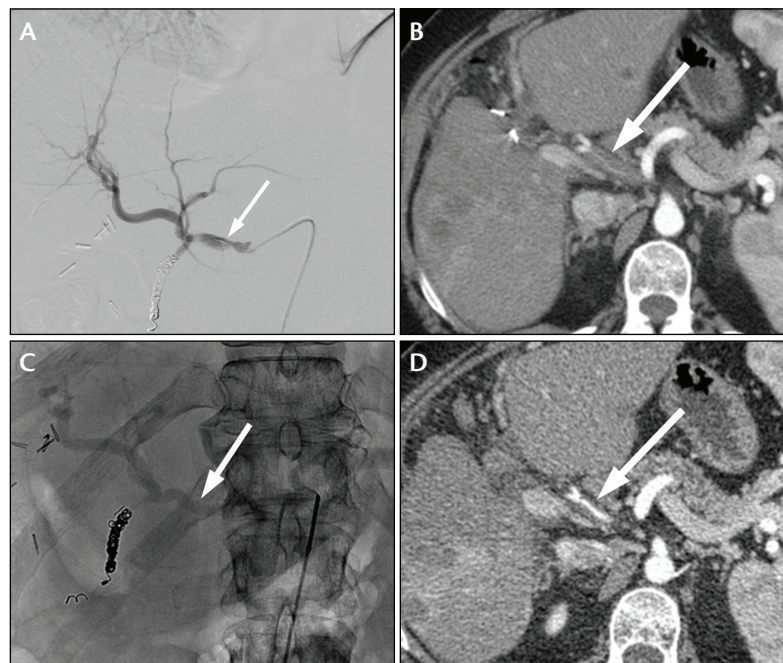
Common hepatic arteriography showed a flow-limiting dissection flap in the common hepatic artery. The GDA had been coiled in preparation for yttrium-90 radioembolization (A). CT performed 2 weeks after the dissection occurred showed a tiny channel of contrast running through concentrically thickened layers of thrombus in the false lumen of the dissected artery (B). Angiography performed 2 months after the dissection occurred showed a widely patent lumen with brisk antegrade flow, allowing for uneventful delivery of radioembolization spheres (C). Corresponding CT showed resorption of the thrombus with restoration of the patent true lumen back to pre-dissection caliber (D).
